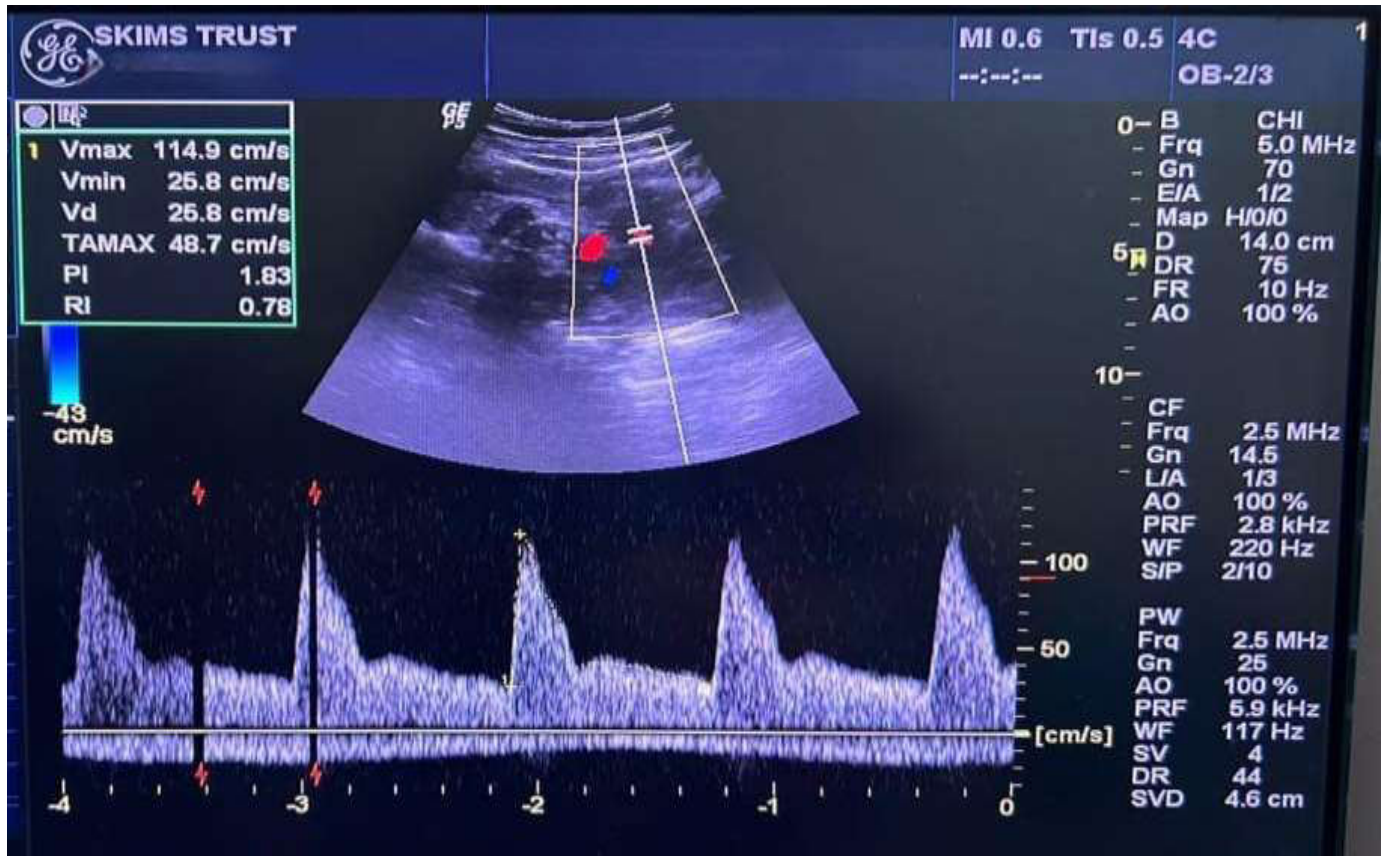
Uterine artery Doppler waveform showing a high-resistance flow pattern with markedly elevated PI and RI values of 1.83 and 0.78, respectively.
